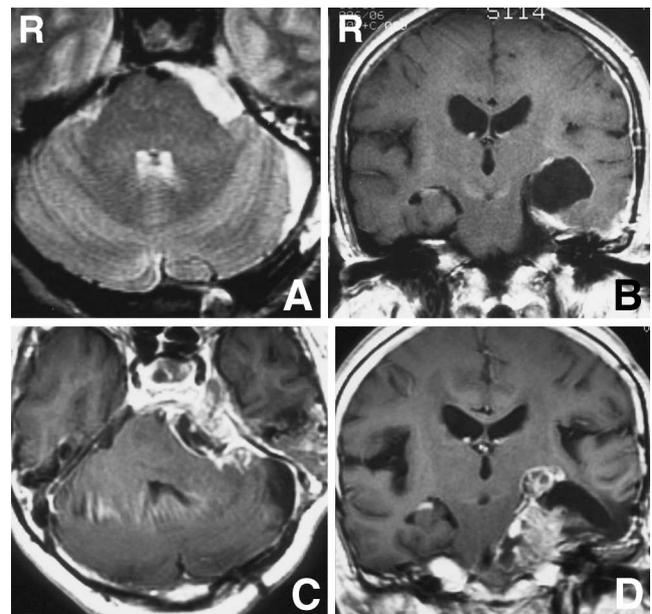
A: Axial T₂-weighted magnetic resonance (MR) image before first surgery revealing a cystic lesion in the left parapontine region. B: Coronal T₁-weighted MR image with gadolinium before first surgery revealing a large cystic lesion extending to the left parapontine region, measuring 3.5 × 2.5 cm in the left medial temporal region with rim enhancement in the tumor capsule. C, D: Axial (C) and coronal (D) T₁-weighted MR images with gadolinium about 12 years after second surgery revealing growth of the cystic lesion with predominant enhancement and severe compression of the pons, mainly located in the left upper portion of the pons and invading the surrounding structures.
